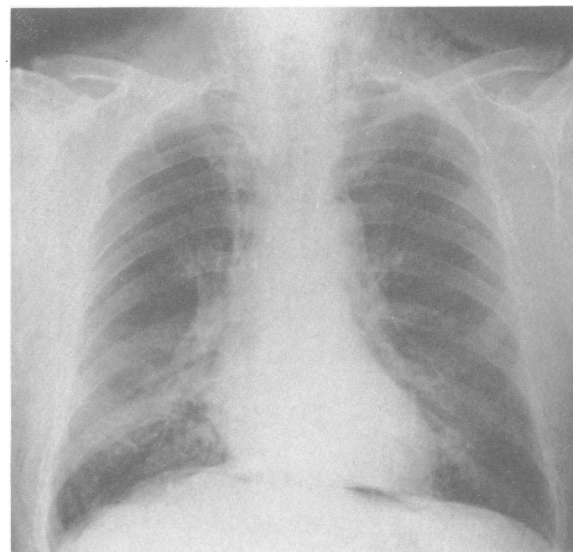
X-ray film of the chest (case 1) showing subcutaneous air in the neck, pneumomediastinum and air under the diaphragm.
